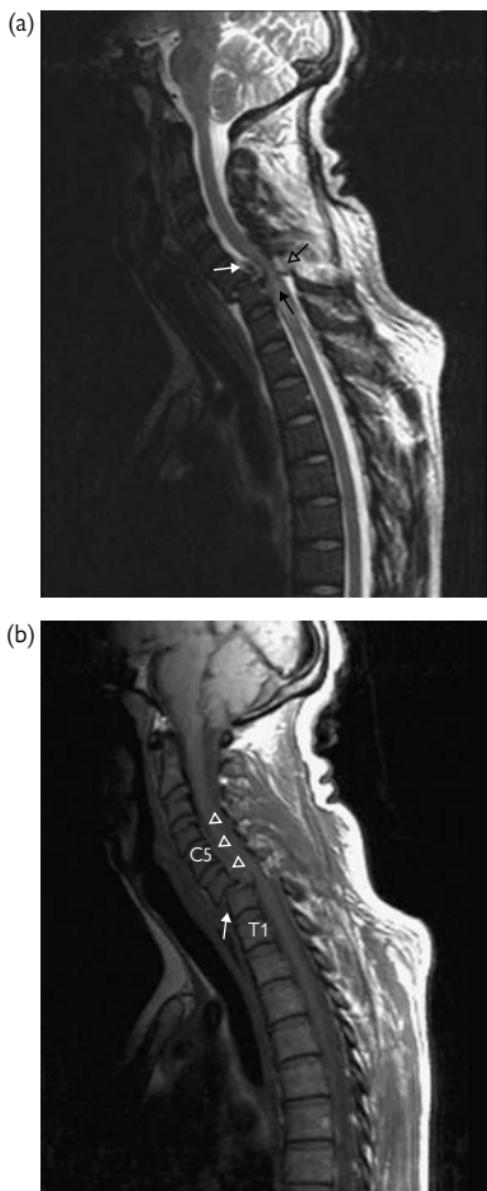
Bilateral facet dislocation. (a) Sagittal T2W and (b) sagittal T1W MRI. Grade 2 spondylolisthesis of C6 upon C7 with large disc protrusion ((a) white arrow), epidural haematoma ((b) open white arrowheads), and rupture of the posterior ligamentous structures ((a) open black arrow). Discontinuity of the anterior longitudinal ligament indicates probable injury ((b) closed white arrow). The spinal cord is compressed and intramedullary signal change, in keeping with oedema, extends from C6 to T1 ((a) closed black arrow). Note the absence of intramedullary hyperintensity on T1W or hypointensity on T2W imaging, which would indicate spinal cord haemorrhage.
